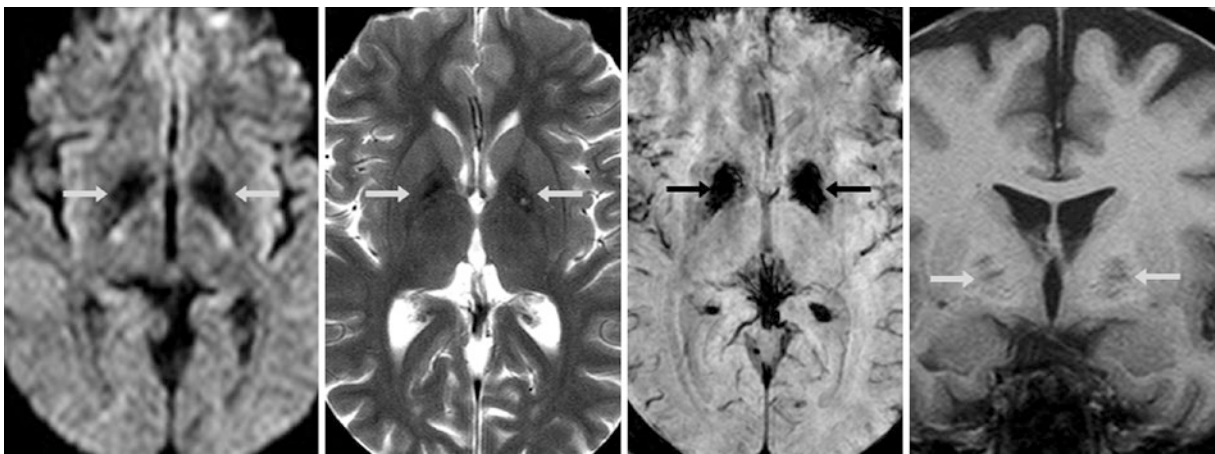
A 1.5 T MRI in a 48-year-old shows T2 blackout (*arrows*). It is dark on DWI (*left*), T2WI (*left middle*), and SWI (*right middle*), from accelerated deposition of pallidal iron, which is disproportionate
